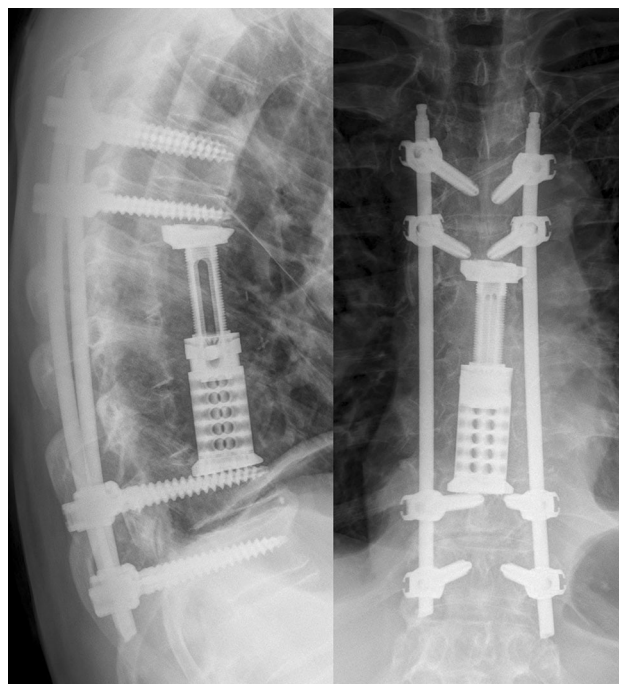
Postoperative X-ray: vertebral body replacement and instrumentation (lateral and a.p. plane)
